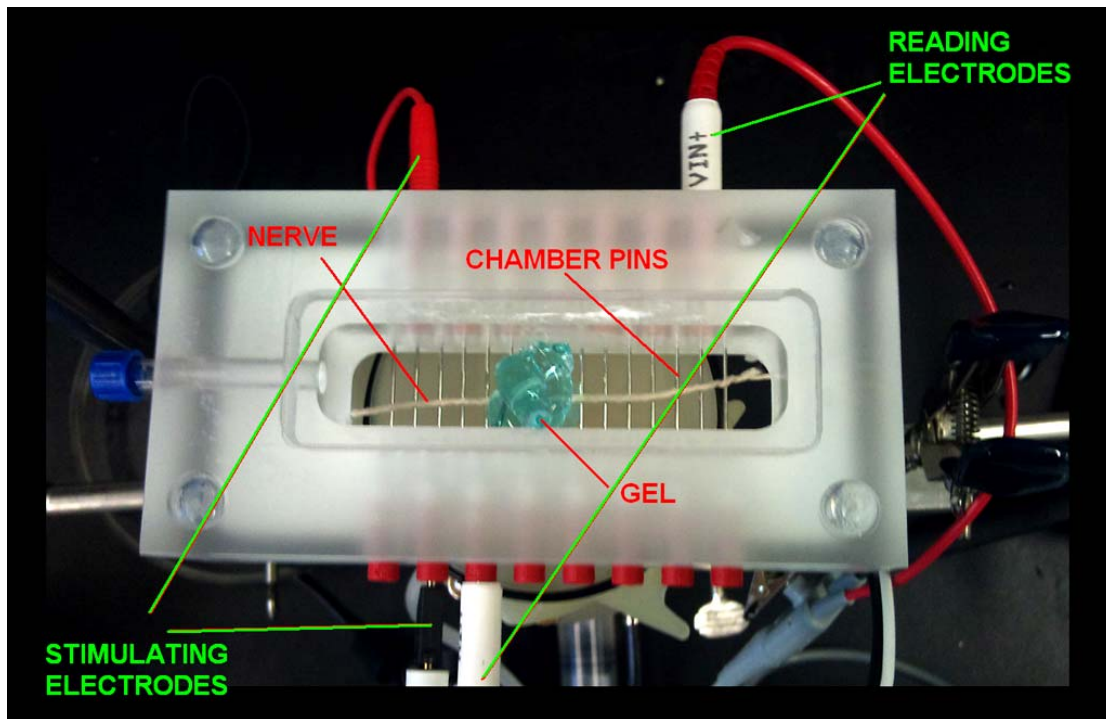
Nerve chamber – Showing the Biopac nerve chamber during an experiment. The nerve sits on the wires of the chamber, while the centre of the nerve is covered with ultrasound gel
